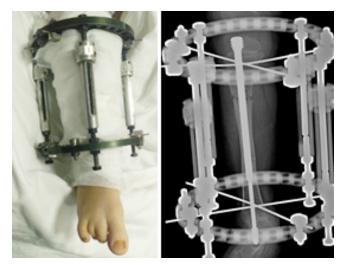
Clinical and X-ray post-op.
